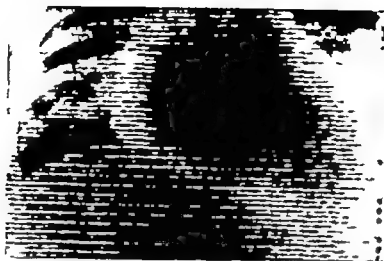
Photoscan superimposed on the chest radiograph of a patient with a small pericardial effusion complicating uremia. There is a fairly large cardiac pool surrounded by a halo of decreased radioactivity
